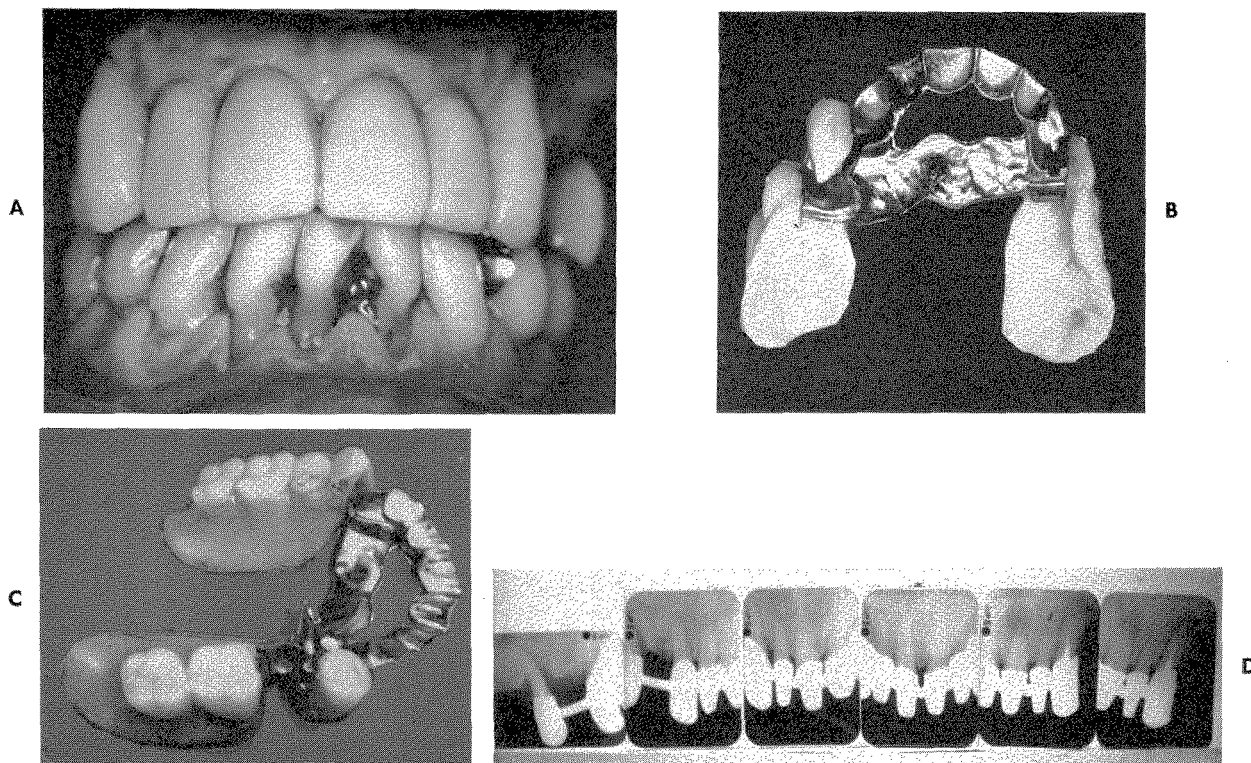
A, Another example of European splinting. Eight-unit upper fixed splint. Seven abutment teeth were used. Three of these teeth were infected. This splint was in only a short time. It supported the removable partial denture shown in B and C. B, The removable partial denture had two complicated breakstress joints which permit movement only in a tissue-wise direction. The removable partial denture locks into the fixed splint by means of two attachments which were released by two small levers operated by the patient. C, The levers are seen here. The extent of the movement of the breakstress in a tissue-wise direction is also shown here. The pity is that so much time was spent in the superstructure when the abutment teeth were so deeply involved in infection. D, Roentgenograms revealing the three infected teeth and the splinting arrangement.
